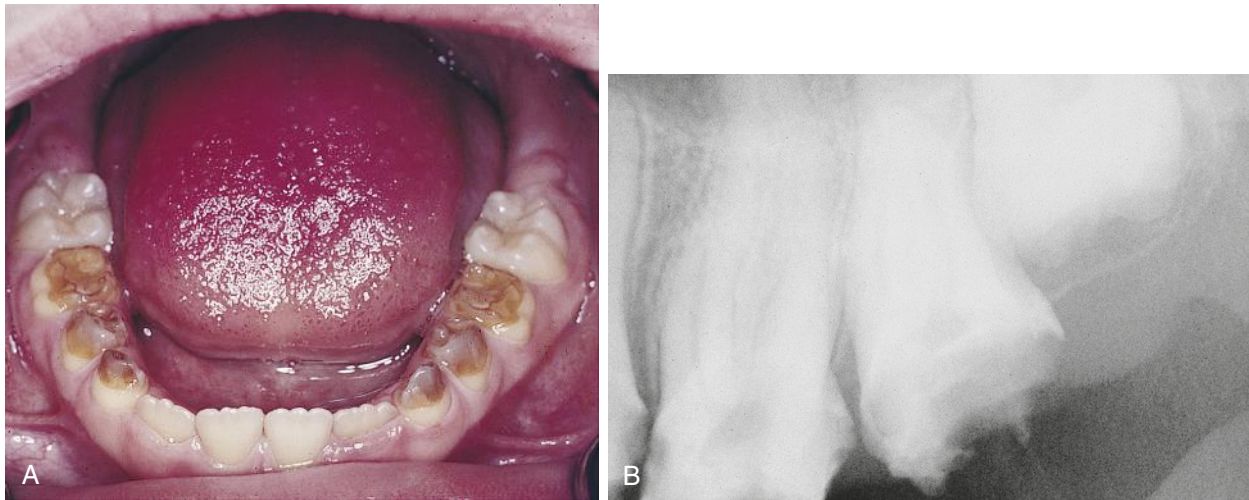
Amelogenesis imperfecta in the permanent dentition. A hereditary type of enamel dysplasia where the teeth have either no enamel or very thin enamel that chips off, leaving the yellow crowns of dentin, which undergo extreme attrition. A, Clinical view. B, Radiograph. (Courtesy of Margaret J. Fehrenbach, RDH, MS.)
